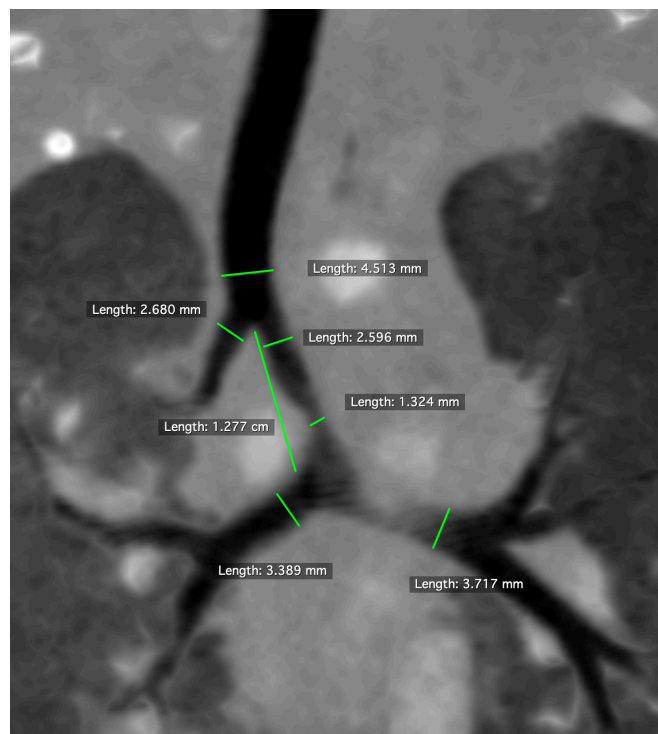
Axial view of computed tomography demonstrated the stenosis of trachea by specific value.
